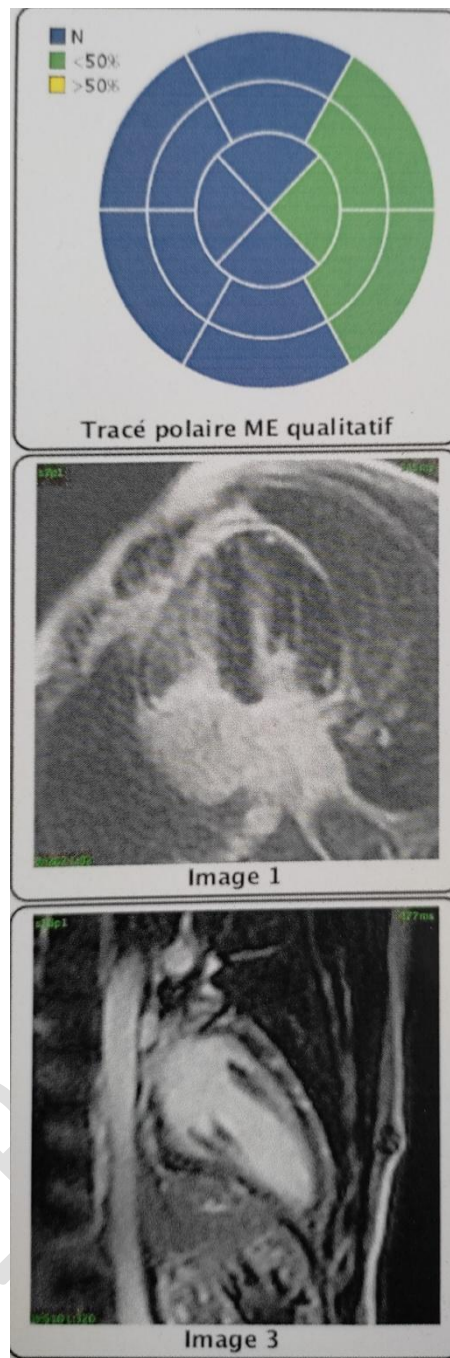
MRI revealing the presence of late enhancement areas in 7 out of 17 LV segments confirming the diagnosis of an acute myocarditis.
